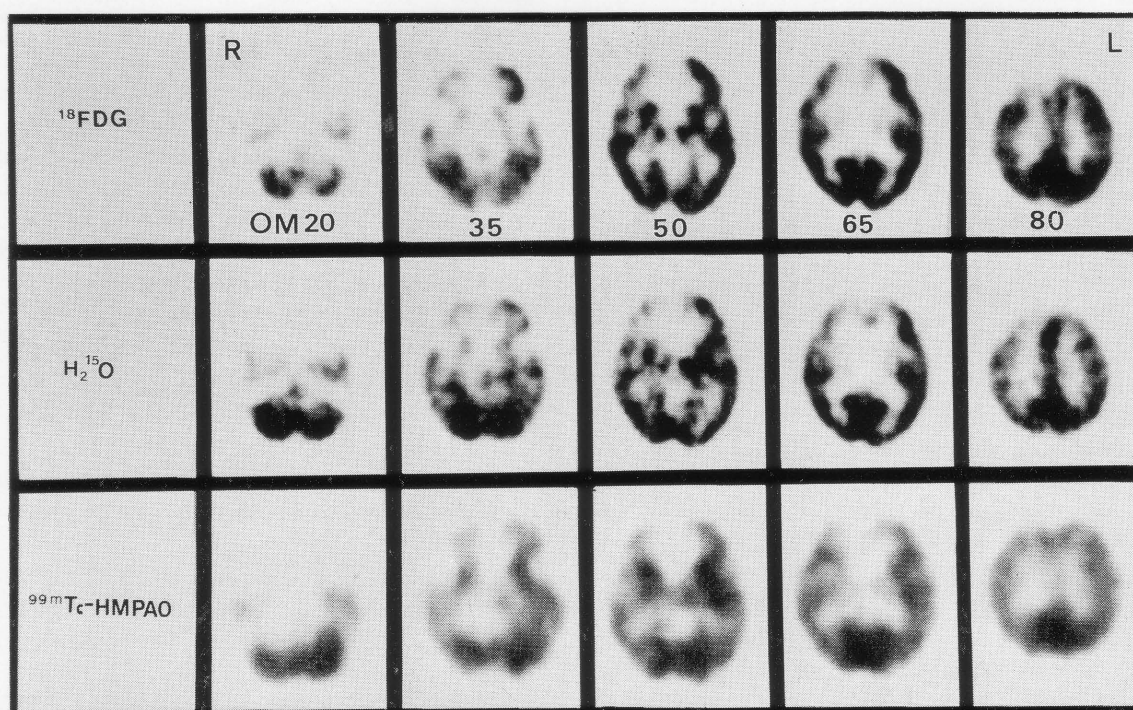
(Pick's disease, 60-year-old female) F-18 FDG PET, 0-15 H₂O and Tc-99m HMPAO SPECT images show decreased CMRGlc and perfusion in the frontal region on both sides.
